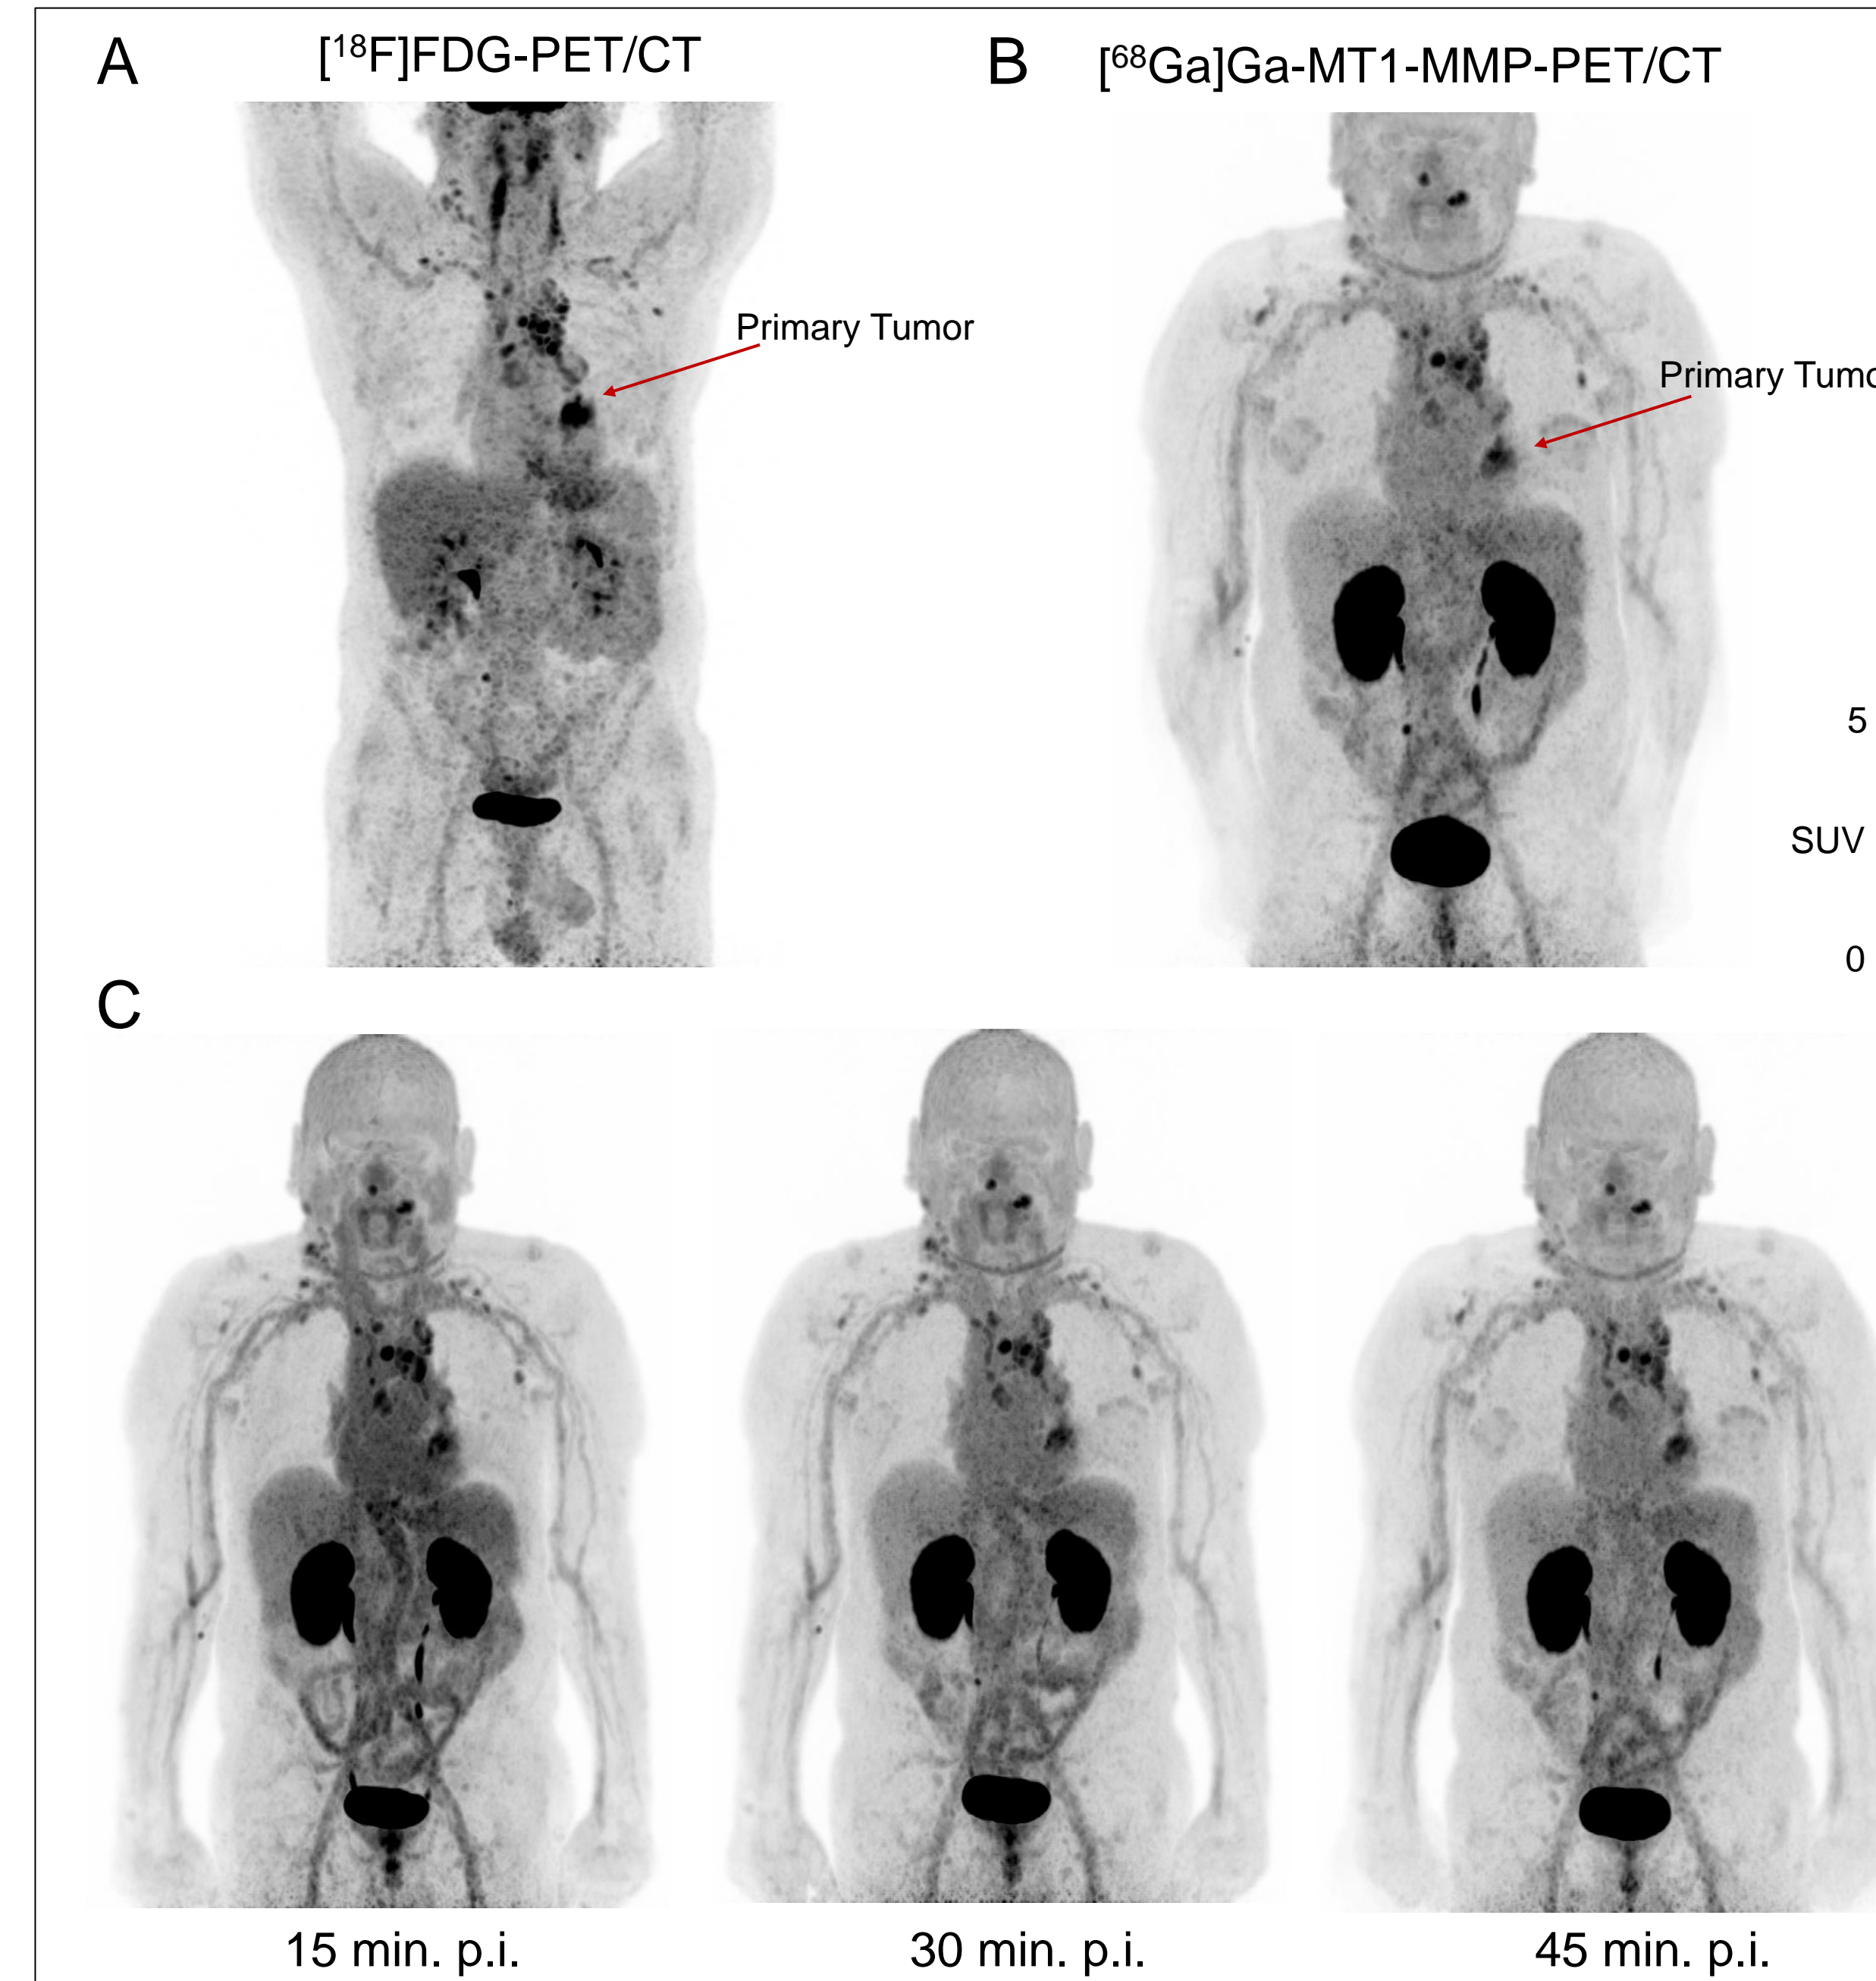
MT1-MMP-PET/CT imaging in advanced pulmonary adenocarcinoma. Maximum intensity projections of [<sup>18</sup>F]FDG-PET/CT (A) and [<sup>68</sup>Ga]Ga-BCY25286 PET/CT at 60 mins (B) and at early time points (C) post injection.
